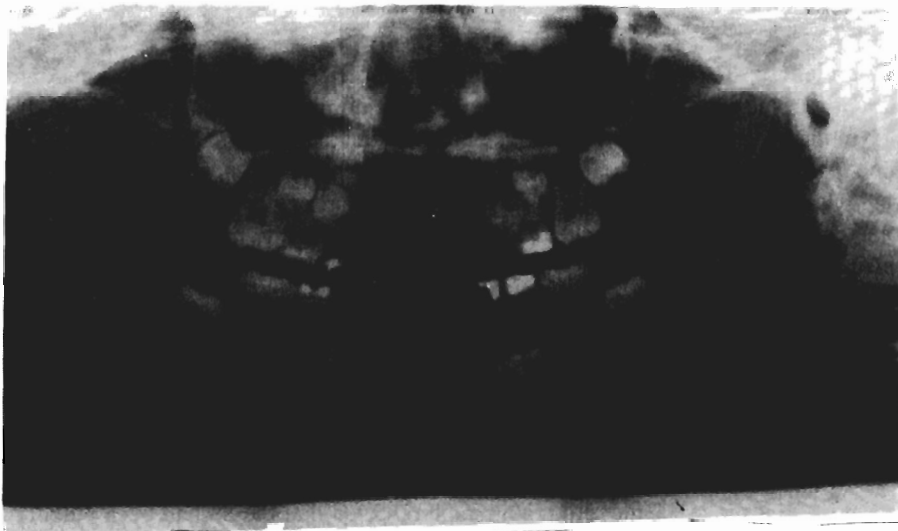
Panoramic view of the jaws showing rotation of tooth number 34 and a periapical lesion on tooth number 74 (Lower left primary first molar).
